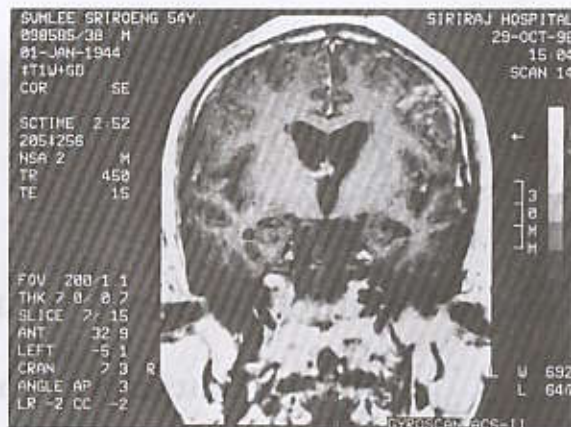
MRI of brain (T1W image) showed hydrocephalus with localised brain infarction over the left frontoparietal region.
